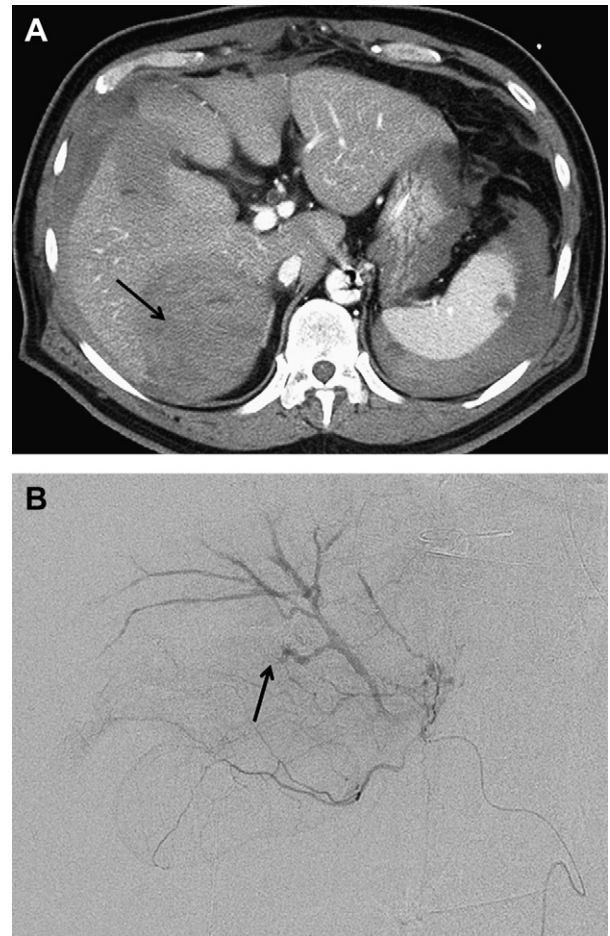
(A) Contrast-enhanced computed tomography scan in the portal phase showing a massive liver parenchymal hematoma in the right lobe (arrow). (B) Selective angiography reveals successful embolization of the posterior branch of the right hepatic artery (arrow).
